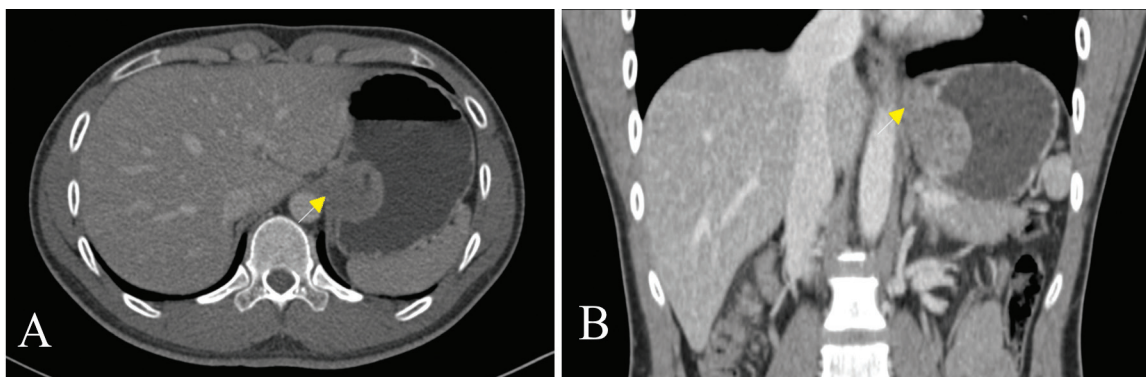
Contrast enhanced computed tomography cuts (A. axial B. coronal) showing the gastroesophageal junction mass (yellow arrow).
